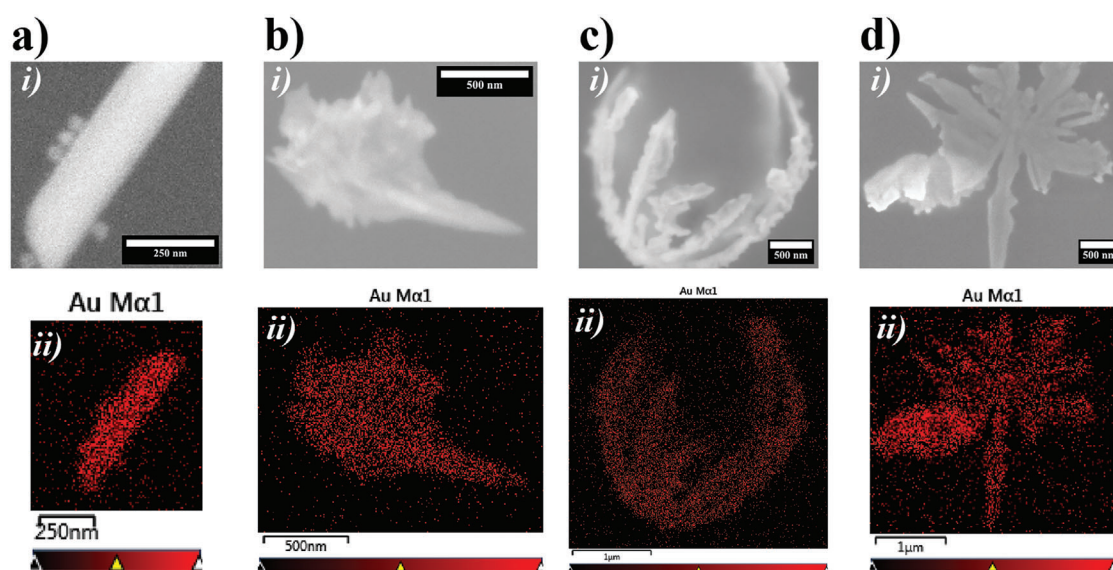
Scanning electron images (SEM, top images) and energy dispersive X-ray (EDS, bottom images) of selected nano-/micro-particles. a) A gold nano-bar, scale bar of 250 nm. b) A gold nano-spike, scale bar of 500 nm. c) A gold microcrown, scale bar of 500 nm (SEM) and 1 μm (EDS). d) A gold-maple leaf, scale bar of 500 nm (SEM) and 1 μm (EDS).
